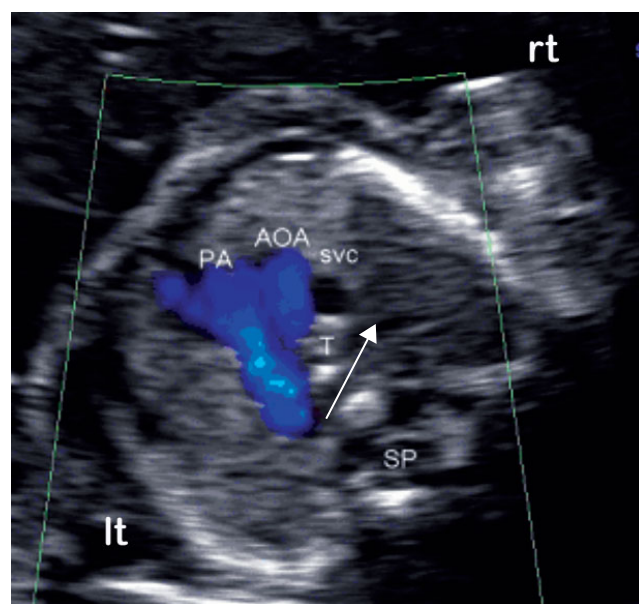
Three vessels and trachea view with color Doppler mapping. Arrow indicates the expected site of origin of the aberrant right subclavian artery. AOA, aortic arch; lt, left; rt, right; PA, pulmonary artery; SP, spine; SVC, superior vena cava; T, trachea.
